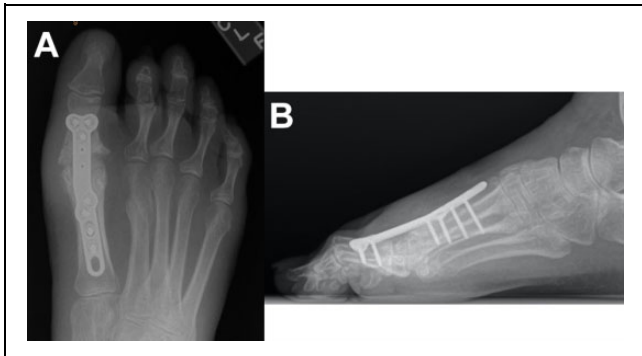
(A) Anteroposterior and (B) lateral radiographs of the right foot taken 3 months postoperatively demonstrating maintenance of alignment, intact hardware, and consolidation of the first MTPJ fusion site. MTPJ, metatarsophalangeal joint.
